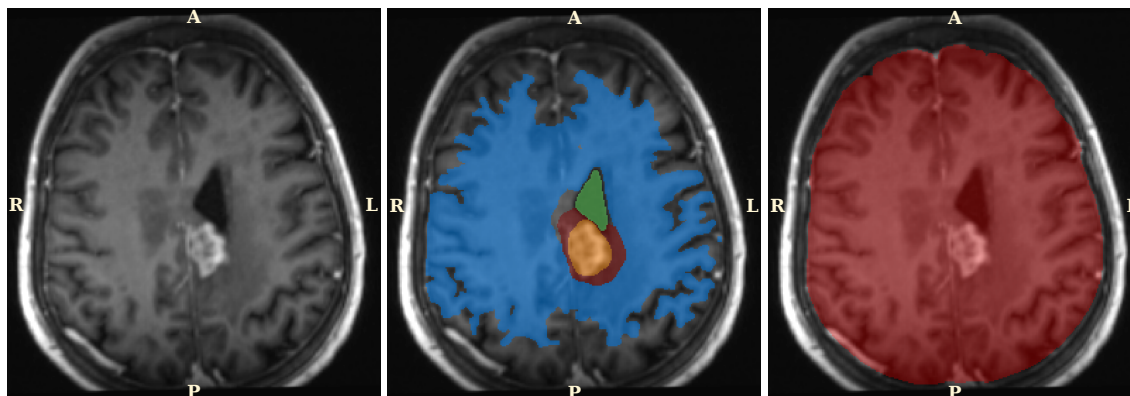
Class mask of patient n^o 3 used for training (middle) and testing (right). The corresponding T_1 weighted contrast enhanced MRI is shown on the left. Class labels are background (c_0 , dark blue), CSF (c_1 , green), healthy brain matter (c_2 , light blue), initial tumor volume GTV (c_3 , orange) and progress tumor volume from the follow up MRI (c_4 , dark red).
